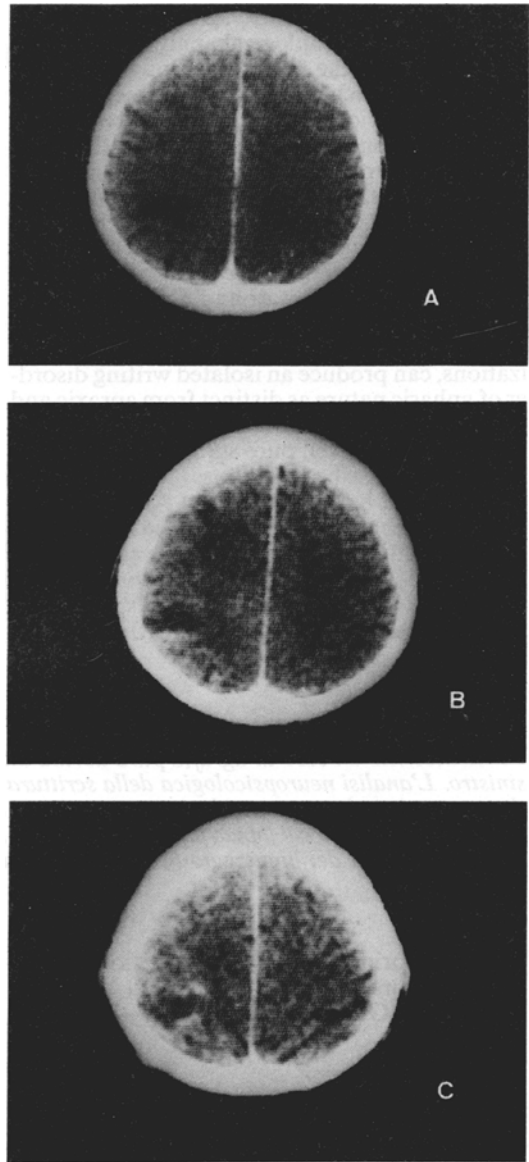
A, B, C. Three successive computed tomographic scans with contrast enhancement showing a small hypodense lesion in the left superior parietal lobule.
